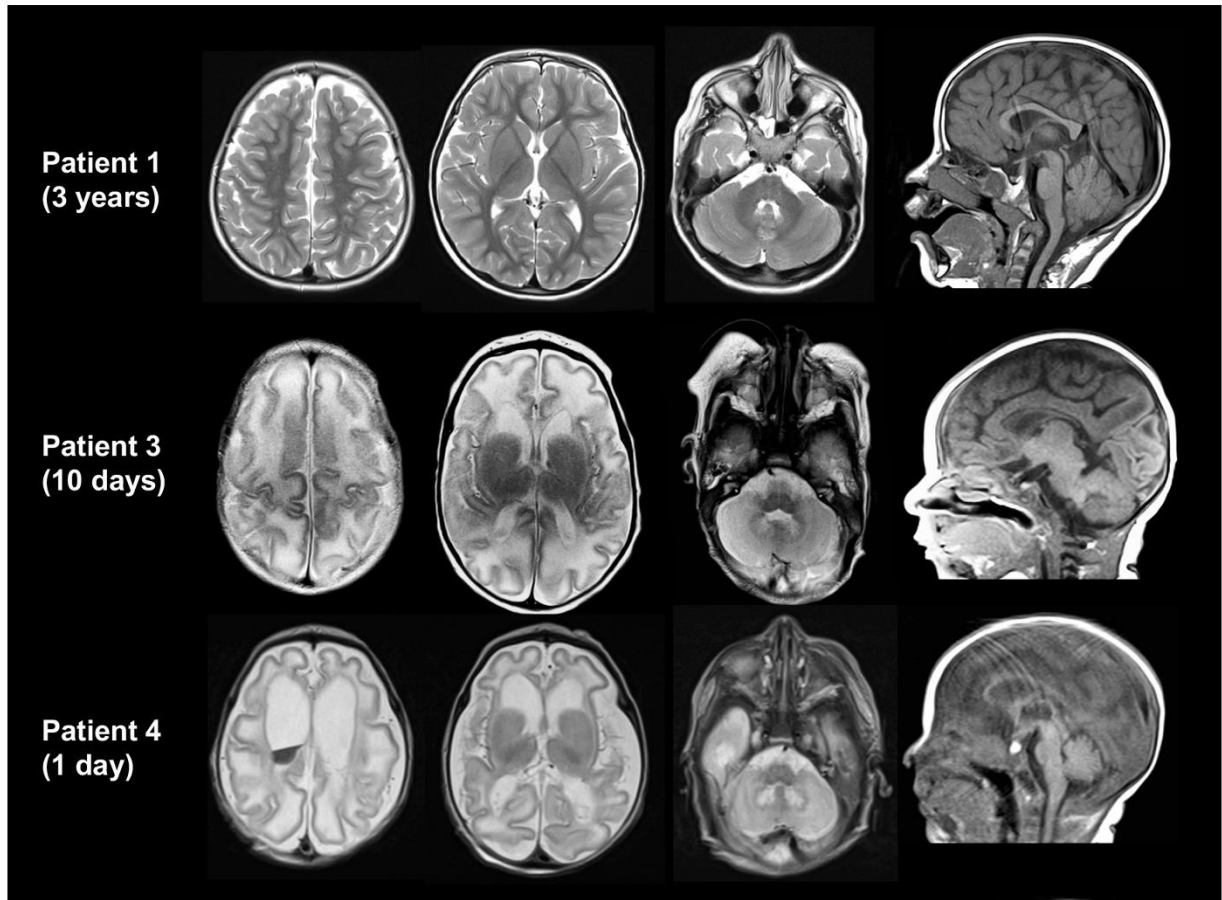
Patient MRI findings.
